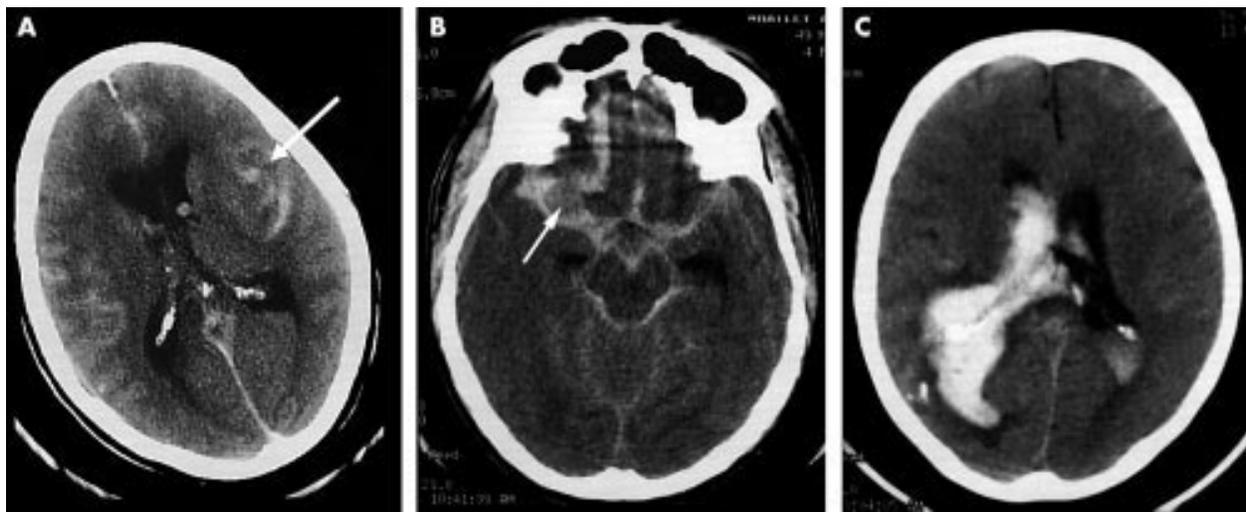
(A) Computed tomographic (CT) scan with diffuse subarachnoid blood maximum in the left Sylvian fissure (arrow). (B) CT scan showing collection of blood in the right Sylvian fissure. A giant aneurysm is seen in this location (arrow). (C) CT scan showing extensive intraventricular blood from rupture of anterior communicating aneurysm.
